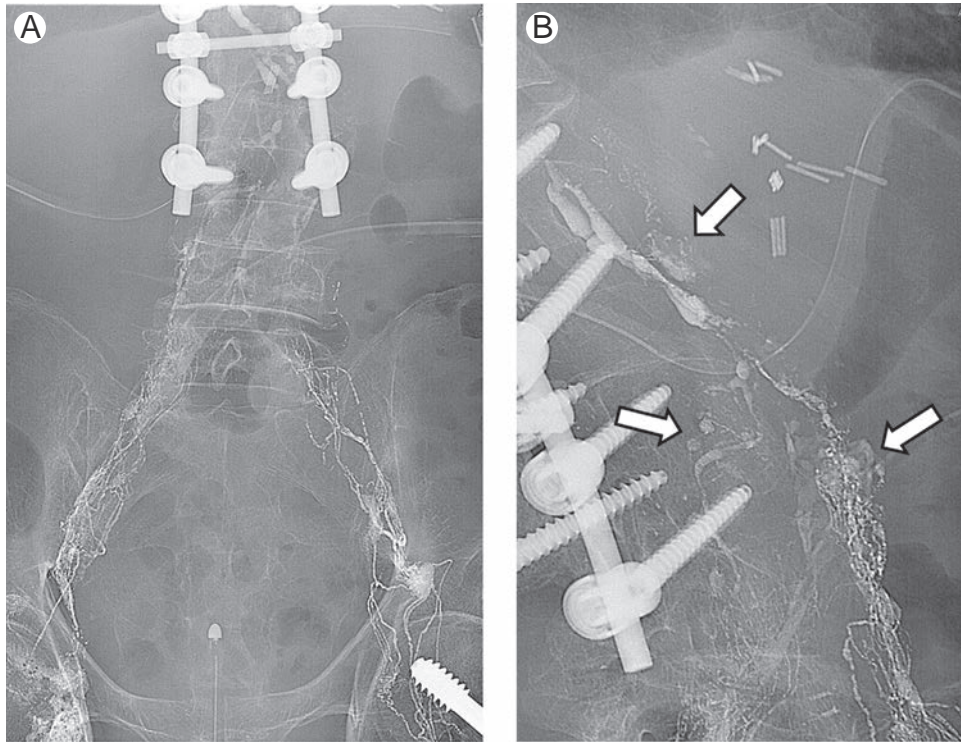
A 68-year-old male patient who developed high-output chylous ascites after esophageal surgery. (A) Intranodal lymphangiography was performed through lymph nodes in bilateral upper thigh regions to assess for lymphatic leakage. (B) Multiple leaks (arrows) were identified in the retroperitoneum on spot radiography. Therapeutic effect of lymphangiography was expected and therefore no further procedure was carried out. The surgical drains were successfully removed 4 days later.
